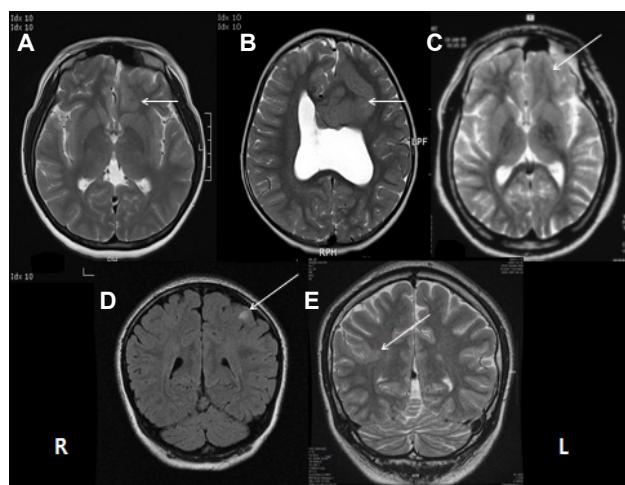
MRI findings of focal cortical dysplasia. (A, B) Thick gyri (arrows), (C) Blurring of cortico-white matter junction, (D) Focal high signal, (E) Transmantle sign.
